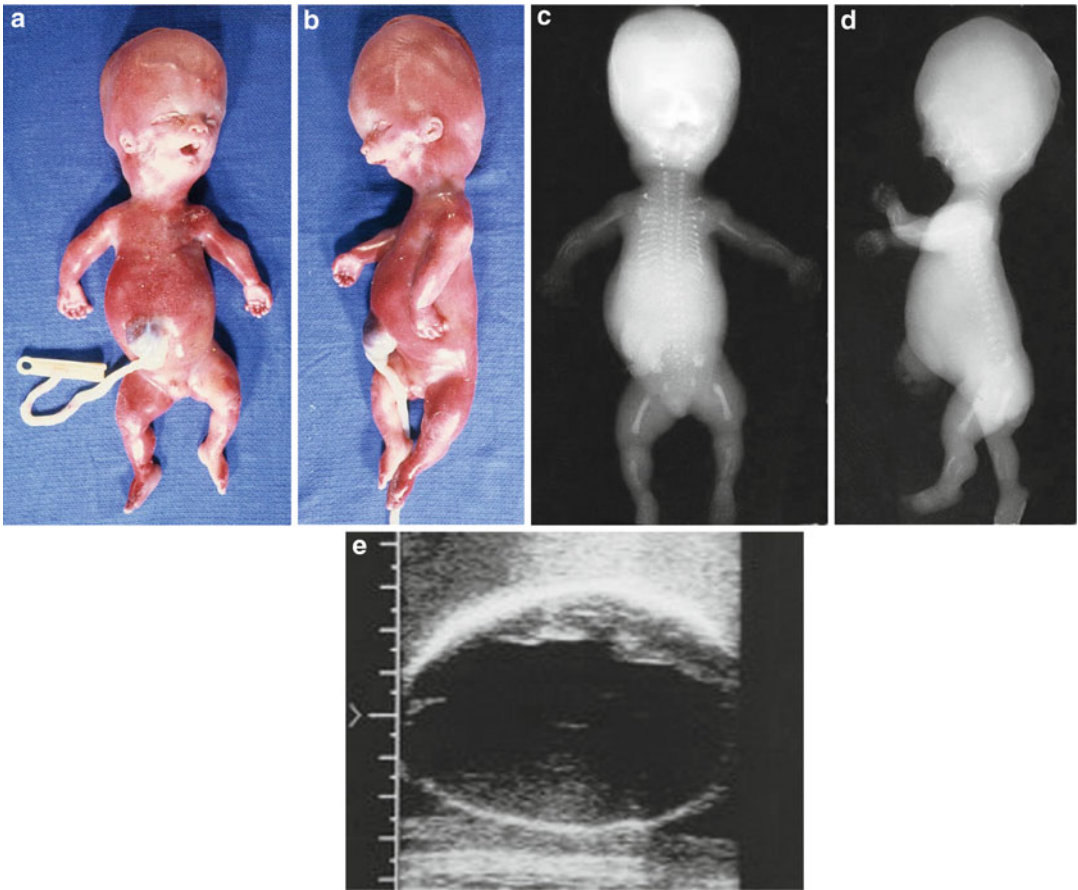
(a–e) A fetus with Beemer-Langer syndrome showing macrocephaly, cystic hygroma, severe micro-/retrognathia with cleft palate, low-set and malformed ears, short limbs, narrow thorax, protuberant abdomen with an omphalocele, and polydactyly. The radiographs show short and horizontal ribs, small scapulae, relatively
